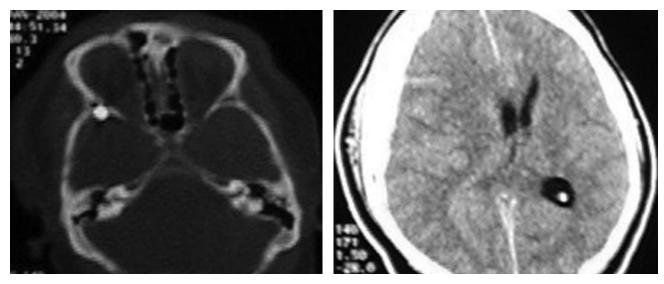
CT image showing the bullet embedded in the skull base at the right temporal tip (Left), as well as a right subdural hematoma with midline shift (Right).
